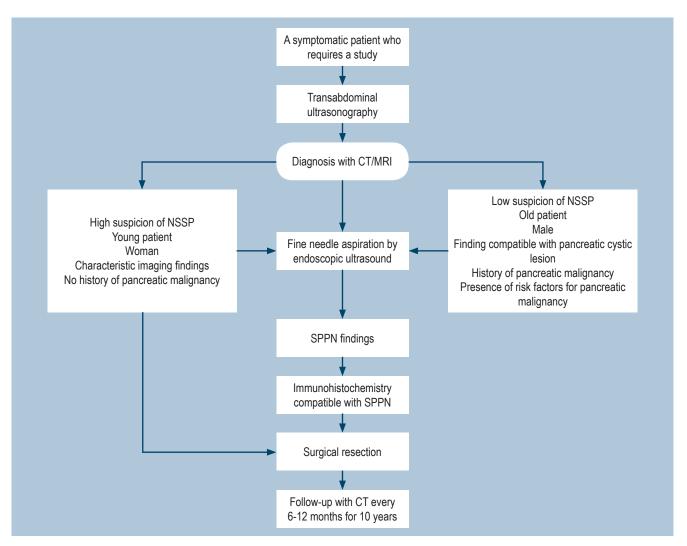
Algorithm for diagnosing, treating, and monitoring SPPN⁽¹⁾. NMR: nuclear magnetic resonance; CT: computerized axial tomography. Modified from: Lanke G et al. World J Gastrointest Endosc. 2018;10(9):145-155.
